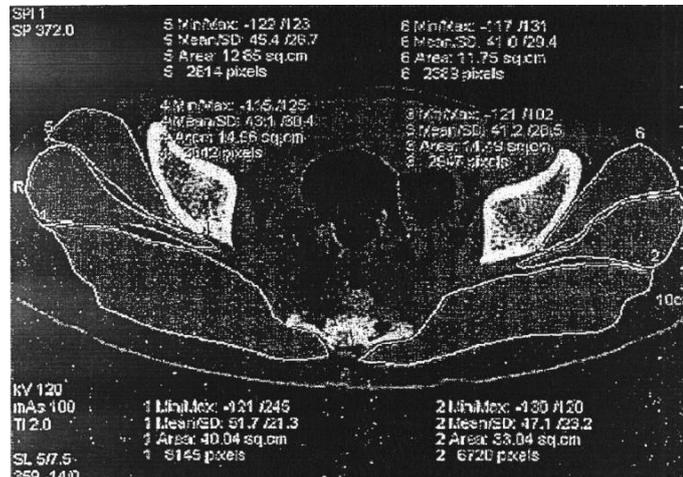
A CT-scan of the cross section of the muscles of the pelvis and hip
